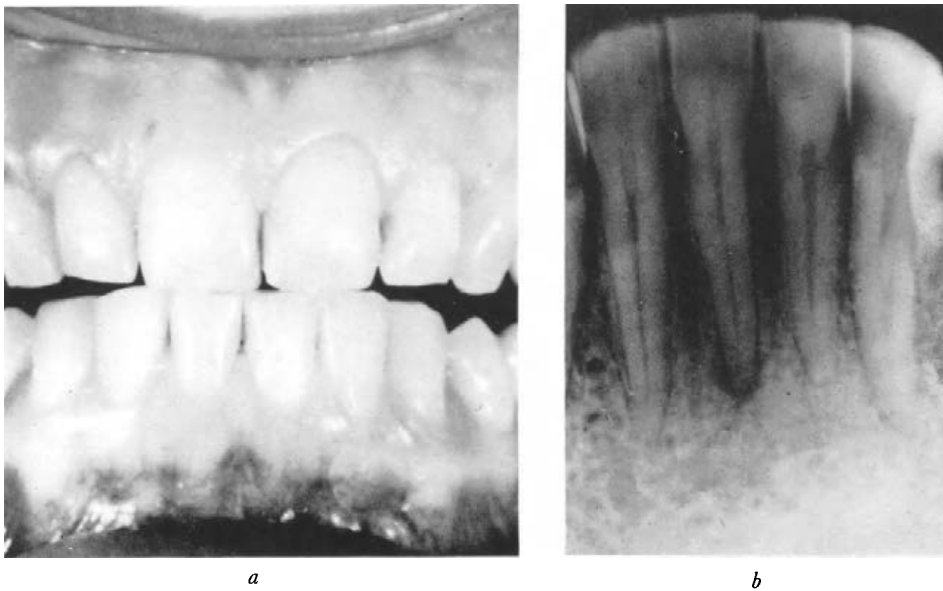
Localized parafunction and death of pulp. *a*, Acknowledged habit. *b*, X-ray of affected tooth.
